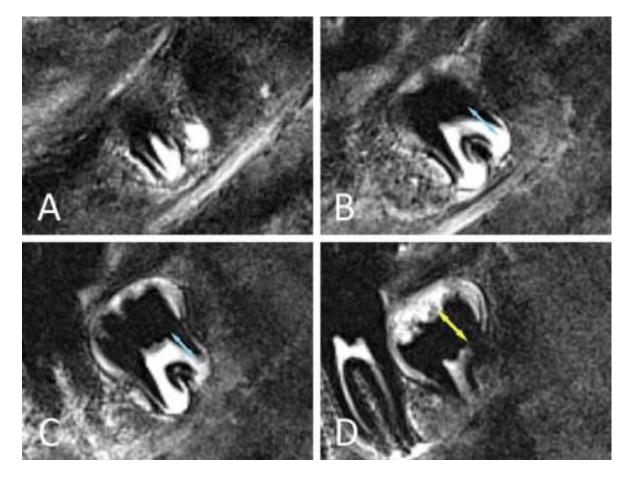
Lower right mandibular third molar depicted on consecutive MRI slices from buccally to lingually. MR crown height is most appropriately measured on slice D. When MR root length would only be based on slice C, stage 3 would be allocated. In fact the tooth is in stage 4, since MR root length on slice B is slightly longer than MR crown height and the root is depicted over several slices (keeping in mind that slice thickness is 2 mm).
